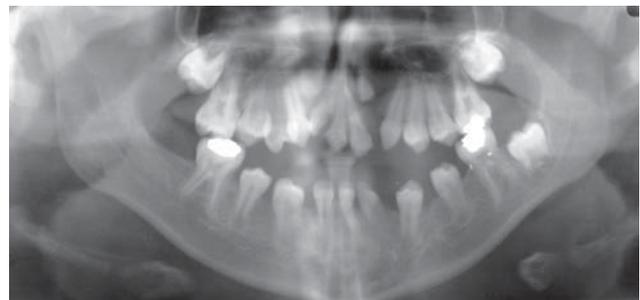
Orthopantomogram radiograph displaying severe hypodontia, rotated and malpositioned teeth.
